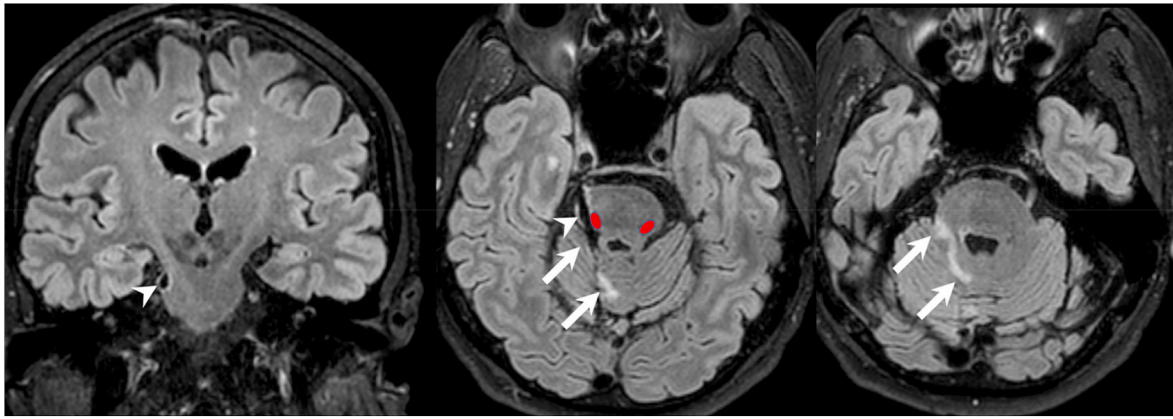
Eighteen years later, FLAIR images demonstrate gliosis along the course of the foil. (A,B) Encephalomalacia and gliosis (white arrowheads) extends into the right lateral basal pons to involve the spinothalamic tract (ovals), (B,C) the superior cerebellar hemisphere, lateral vermis and superior right brachium pontis (white arrows).
